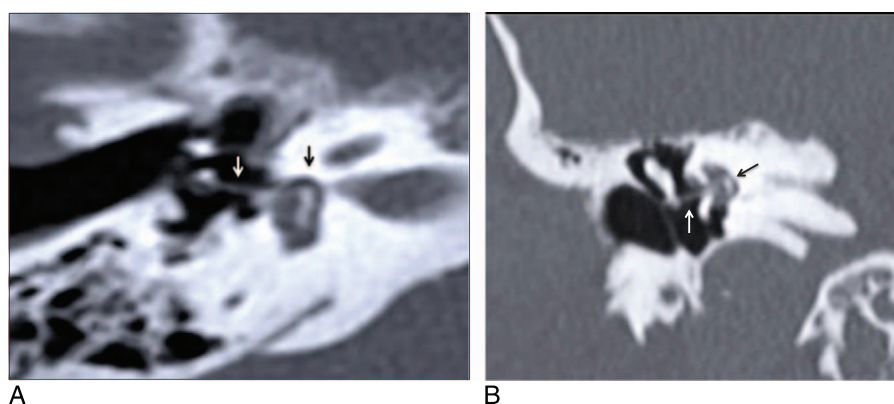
A, Axial CT scan showing the presence of the stapes entirely in the vestibule (black arrow) and the stapes prosthesis in position (white arrow). Interesting to note that the footplate is filling the spherical recess in the medial wall of the vestibule where the saccule is located. B, Coronal section showing another view of the presence of the stapes entirely in the vestibule (black arrow) and the stapes prosthesis in position (white arrow).
